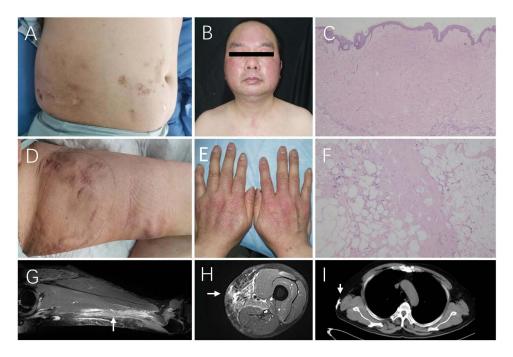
(A and D): The cicatrix, fibrocollagenous nodules and multiple calcifications in abdomen and thighs. (B and E): The characteristic features of dermatomyositis: Heliotrope sign, V sign and Gottron sign. (C) (HE×40) and (F) (HE×100): Biopsy of the subcutaneous firm nodules in the trunk revealed localized collagen hyperplasia in the dermis, accompanied by significant mucin deposition, as well as adipose septal fibrosis and hyalinization in the subcutaneous adipose tissue, featuring lipomatous cysts and membranous changes, with a minor infiltration of lymphocytes in the dermis and subcutaneous adipose tissue. (G and H): TI-weighted MR images revealed high signal intensity in sartorius muscle (white arrows) and intermuscular space. (I): The chest CT scan identified subcutaneous calcified nodules (white arrow).
